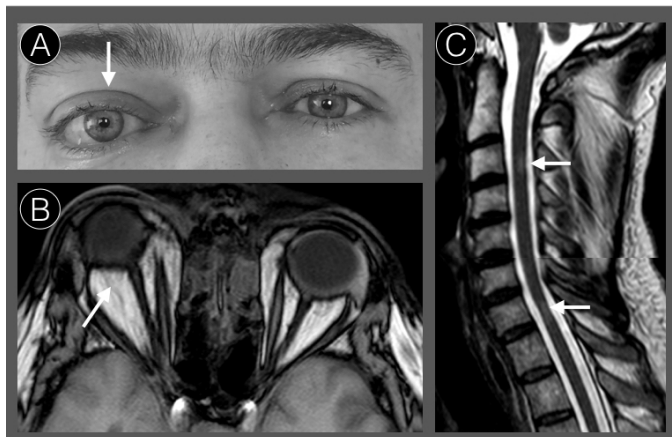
Exophthalmus in an acute MS episode. (A) Clinical presentation of exophthalmus of the right eye (arrow) and diplopia. (B) Transversal T2-weighted MRI with protrusion of the right eye and proliferation of intra-orbital fat tissue (Comerci, Elefante et al. 2013). (C) Sagittal T2-weighted MRI with two spinal lesions (arrows), the lesion in the upper cervical spine (C3, upper arrow) showed gadolinium enhancement and was most likely the reason for the acute paresis of the left hand.
